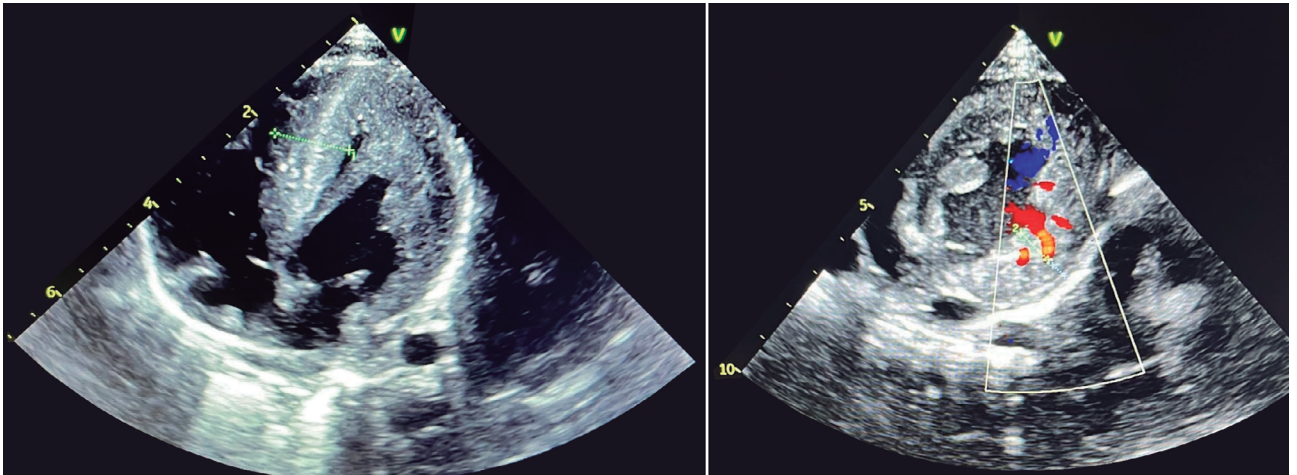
Echocardiogram on the first day of life shows patent foramen ovale and interventricular septum with marked hypertrophy
